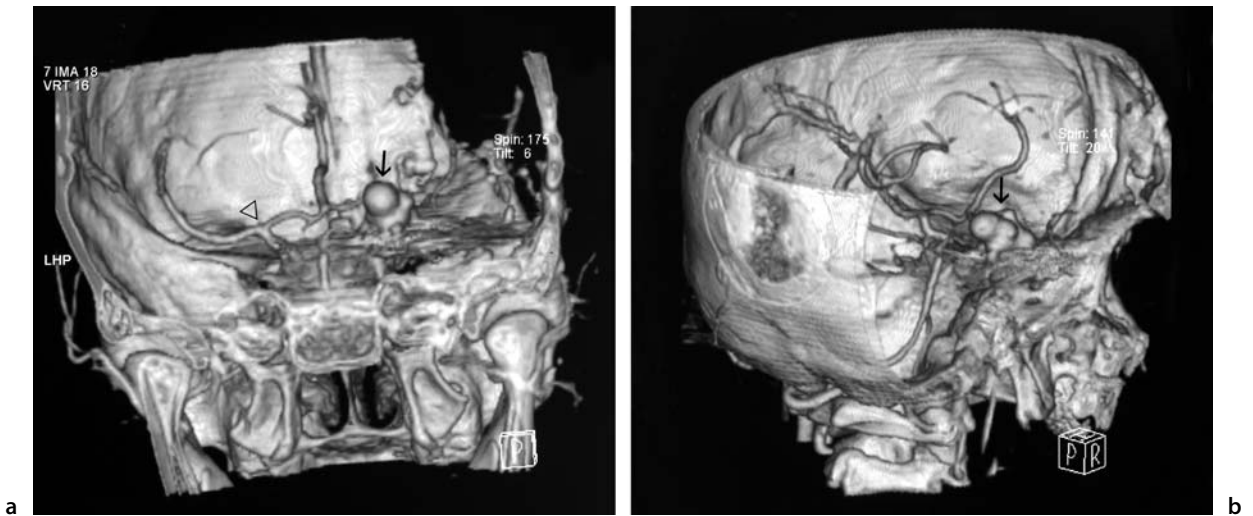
CTA in three-dimensional reconstructive format
